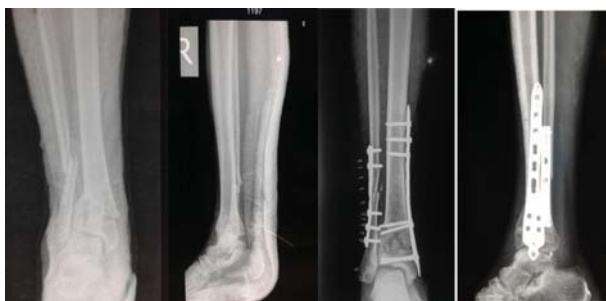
pre and post operative radiograph
